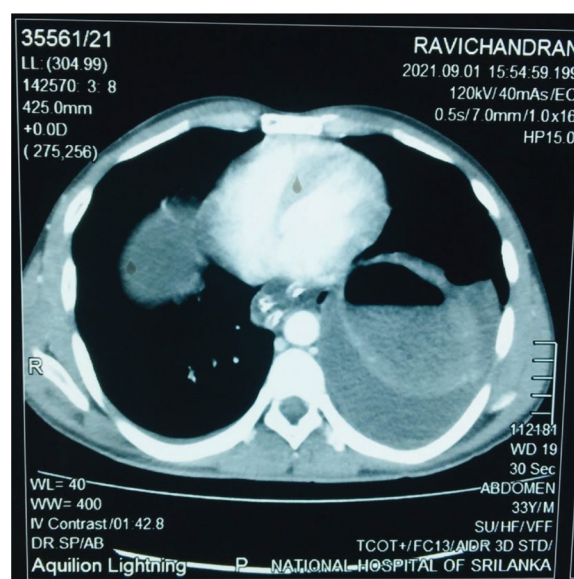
CT scan showing protrusion of abdominal contents into left thoracic cavity.
